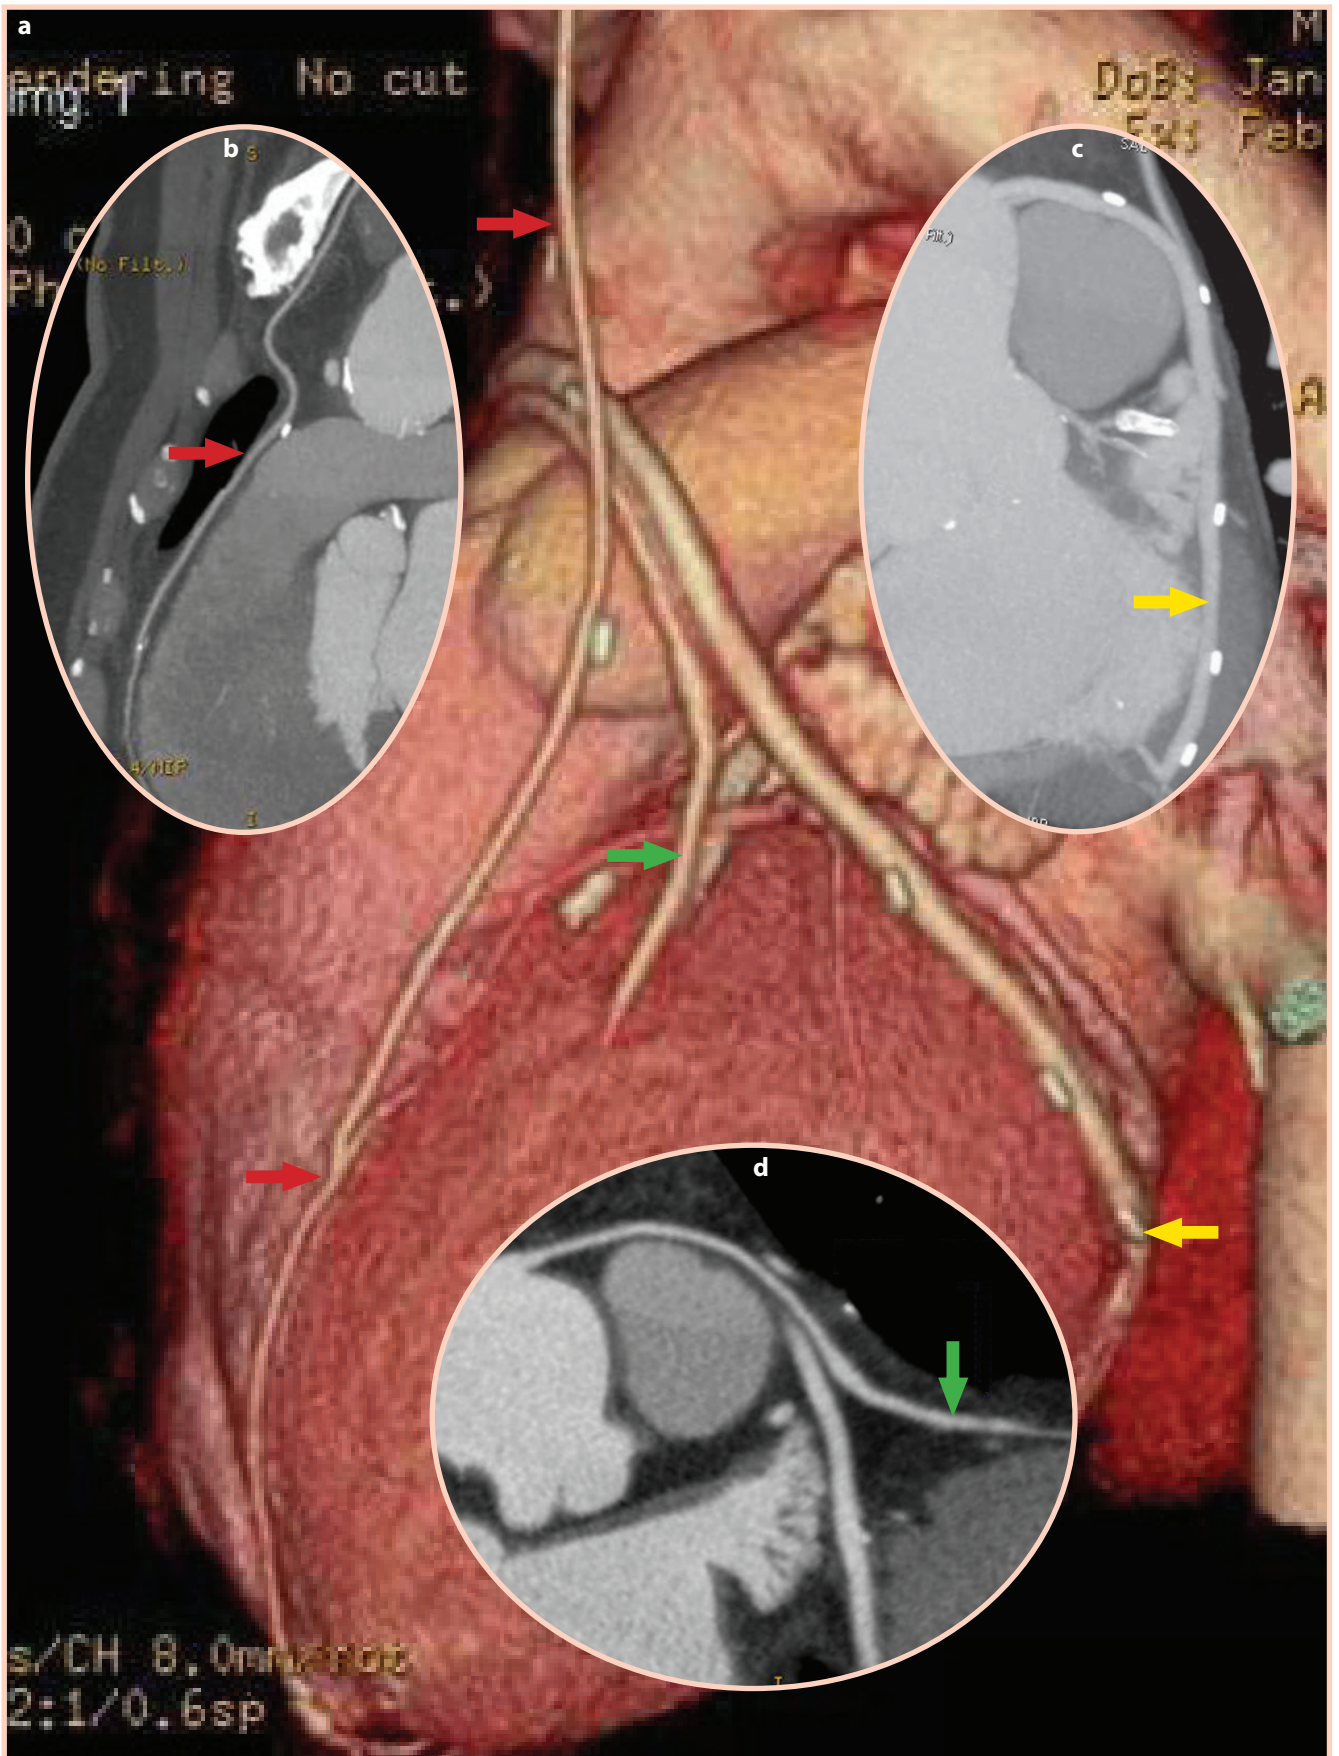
CT preview of the grafts of LIMA on LAD (a and b, red arrow), LRA on RD1 (a, green arrow) and Venous graft on LCX (c, yellow arrow).
